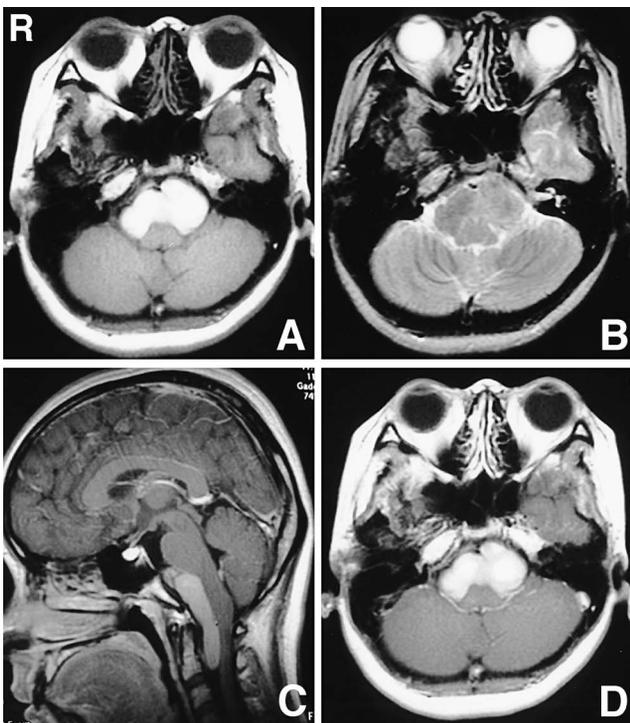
Magnetic resonance images demonstrating a lobulated cystic lesion located ventral to the lower brain stem and the upper cervical cord, with homogeneous high intensity contents on the T₁-weighted image (A) and iso-low intensity contents on T₂-weighted image (B), and no rim enhancement after gadolinium administration (C, D).
